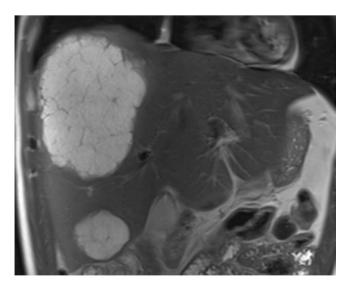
Magnetic resonance imaging demonstrating multiple large hepatic CRC metastases that previously would have been considered unresectable. Criteria for resection have expanded with neoadjuvant chemotherapy, three-dimensional imaging technology, and portal vein embolization facilitating more precise assessment and optimization of the future liver remnant
